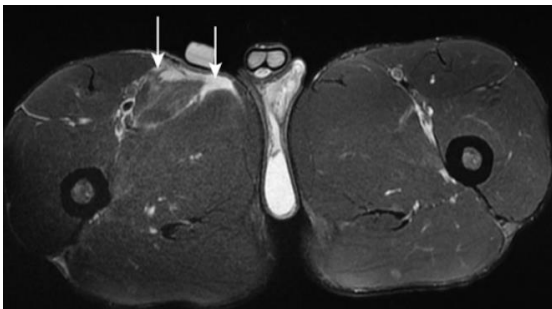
Axial PD STIR MRI slice. Complete detachment of the right long adductor.
